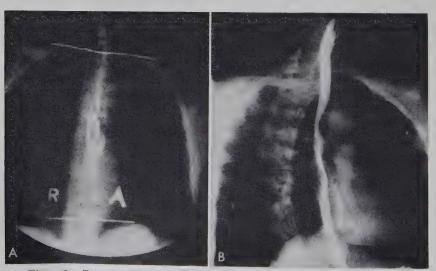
Roentgenograms show large tumor of the middle third of the esophagus (A) before irradiation and (B) after irradiation.
